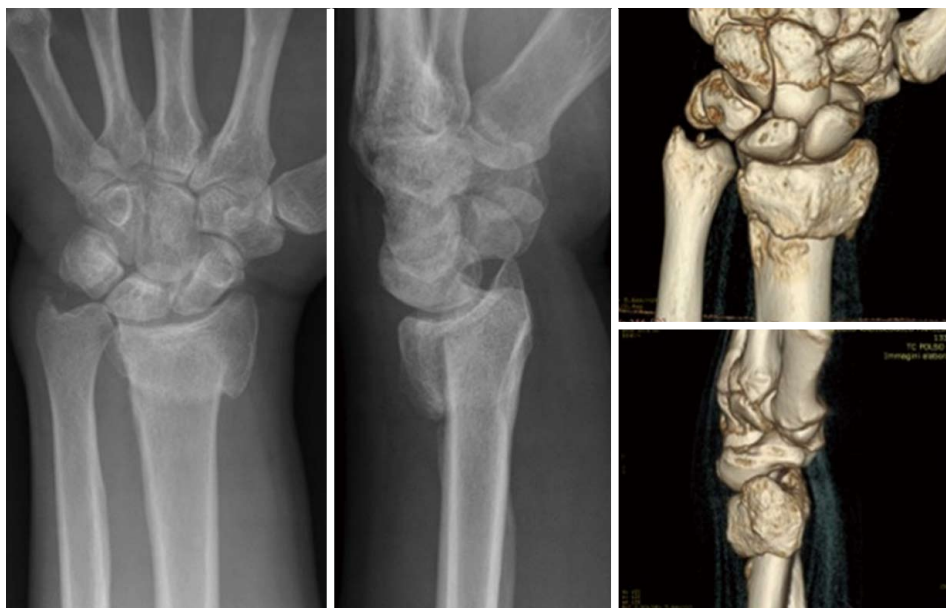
Preoperative X-rays and 3D-computed tomography evaluation showing an extra-articular dorsal malunion in a 36 years old man.
